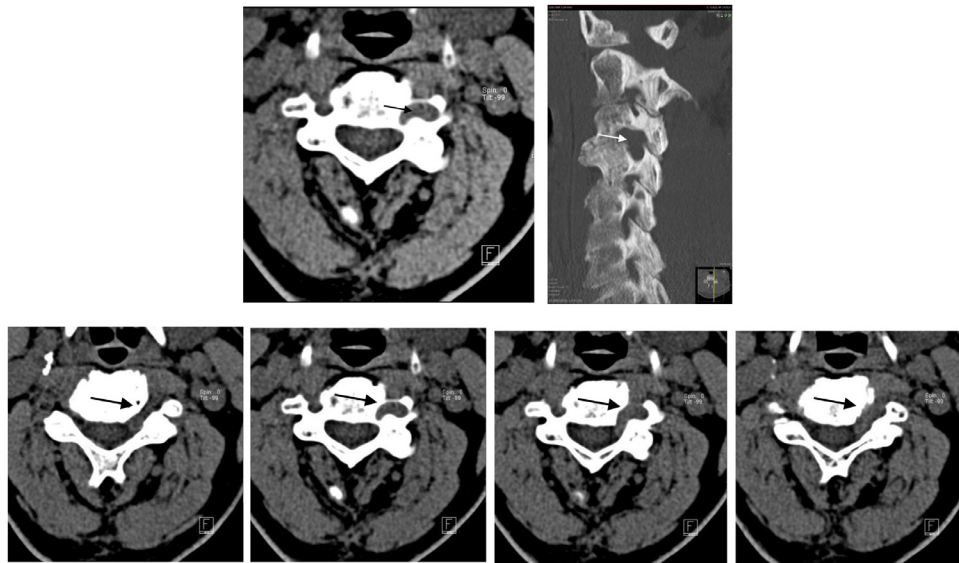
Axial computed tomography scan obtained at the level C3-C4 (A) and sagittal computed tomography scan (B) show an added tissue structure within the widened left C3-C4 foramen along with bony scalloping. (C) A consecutive sequence of the axial compute tomography slices shows the course of the artery in relation to the left C3-C4 foramen.
